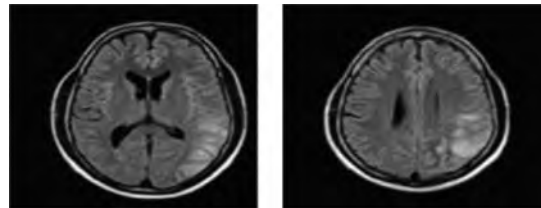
Brain MR image (samples) [24].
